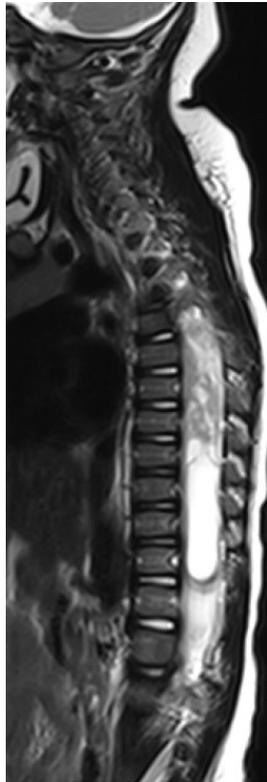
Magnetic Resonance Imaging, T2-weighted, of the thoracic spine lesion extending from level T1 to T11.
